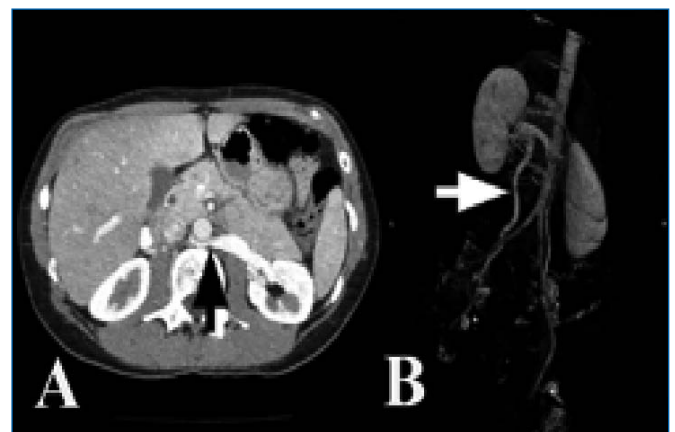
Posterior nutcracker syndrome A: Computed tomography angiogram showing the posterior location of the left renal vein with stenosis (black arrow) and proximal dilatation. B: Major reflux in the left ovarian vein (white arrow) with pelvic varices (posterior view)
